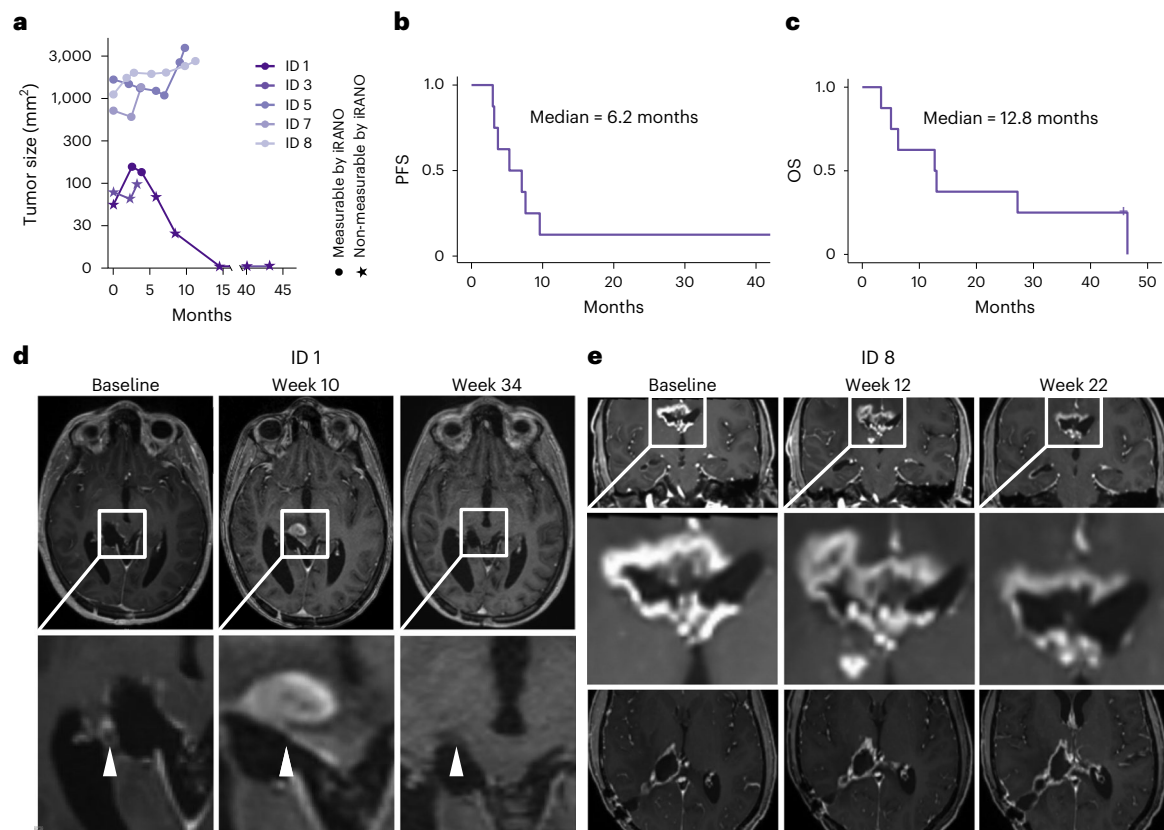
Clinical response to H3K27M-vac. a, Tumor size in mm² as a function of time in months from start of vaccination. Size determined by product of maximal orthogonal diameters on T1-weighted contrast-enhanced MRI imaging. Dots indicate measurements that are considered measurable by iRANO criteria (cerebral lesion with diameter >10 mm). b, c, PFS (b) and OS (c) since the start of vaccination. d, T1-weighted with contrast enhancement (CE) MRI sequences
